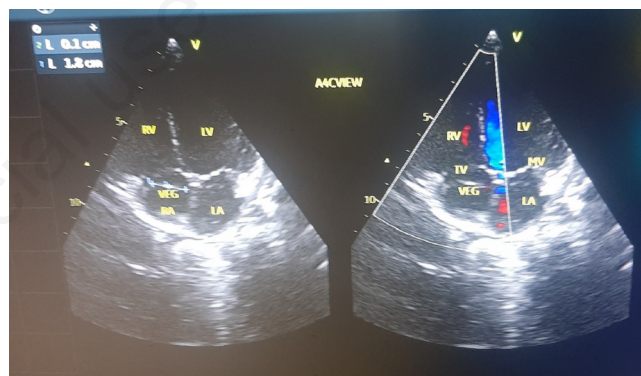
Modified apical four-chamber (coronary sinus) view transthoracic echocardiogram showing a vegetation (VEG) attached to the posterior wall of the Coronary Sinus (CS), extending into the Right Atrium (RA); it measured 18 mm by 1 mm.
